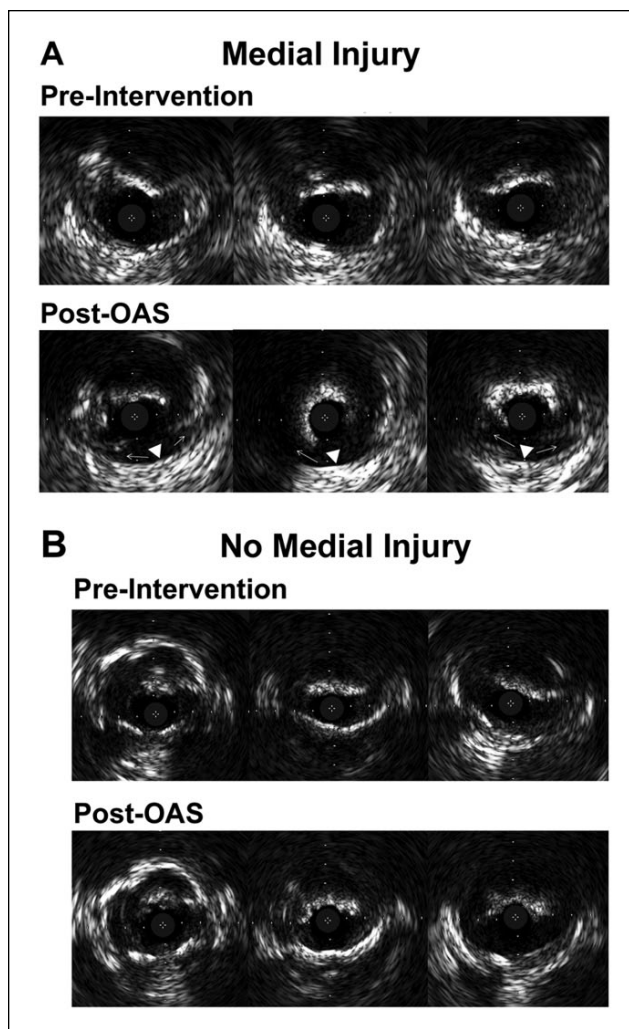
Intravascular ultrasound images of 2 femoropopliteal lesions before (upper panels) and after (lower panels) treatment with the orbital atherectomy system (OAS). In A, there is a monolayer appearance (arrowheads in lower panel) of the arterial wall after OAS, indicating disappearing medial and intimal layers in the middle of a medial dissection (small arrows). In B, there is neither a new arterial wall monolayer nor a new medial dissection after OAS.
